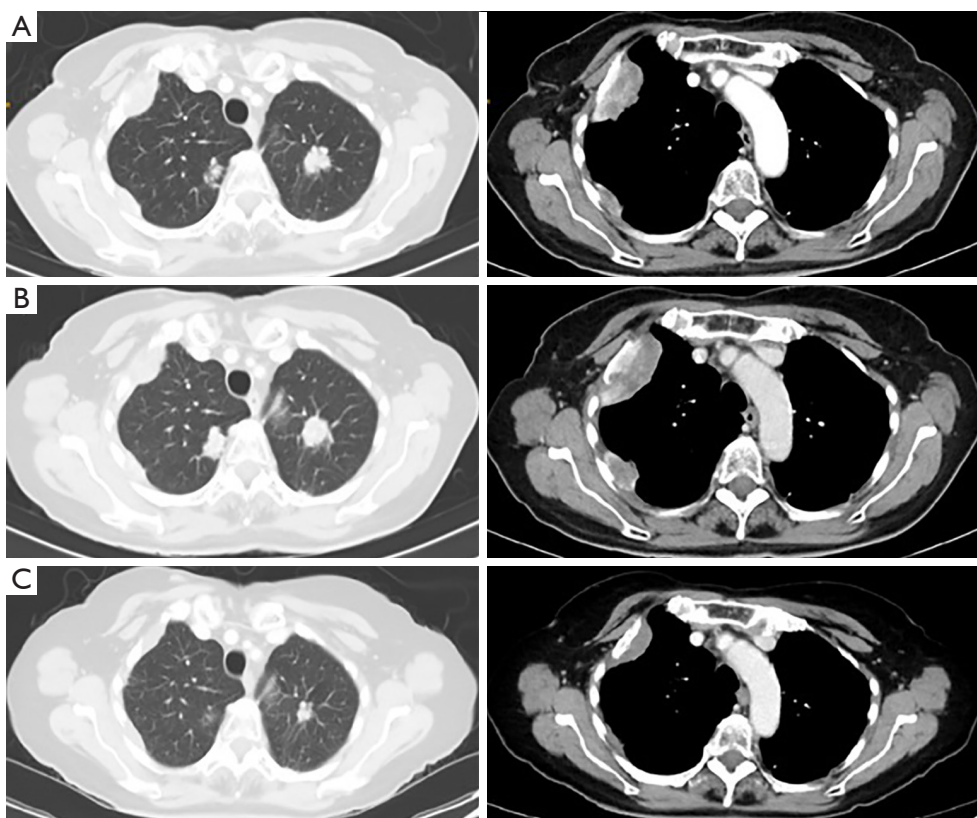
Radiological evolution of the lesions. (A) CT of 01/10/2021: 3 main nodules before RT (16 mm in the right pulmonary apex, 20 mm in the left pulmonary apex, and 5 cm × 2.2 cm 2nd costal arch invading pleural mass). (B) CT of 03/21/2022: evolution of tumoral lesions one month after RT (21 mm in the right pulmonary apex, 23 mm in the left pulmonary apex, and 5.7 cm × 2.5 cm 2nd costal arch invading pleural mass). (C) CT of 11/23/2022: evolution of tumoral lesions nine months after RT (15 mm in the right pulmonary apex, not measurable in the left pulmonary apex, and 13 mm 2nd costal arch invading pleural mass). CT, computed tomography; RT, radiotherapy.
